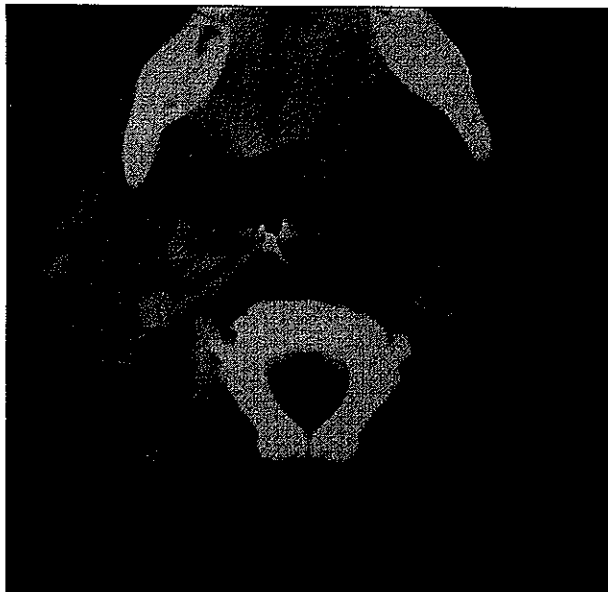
Computed tomographic scan demonstrating a left peritonsillar abscess with gross edema of the soft tissue compromising the oropharyngeal airway.
